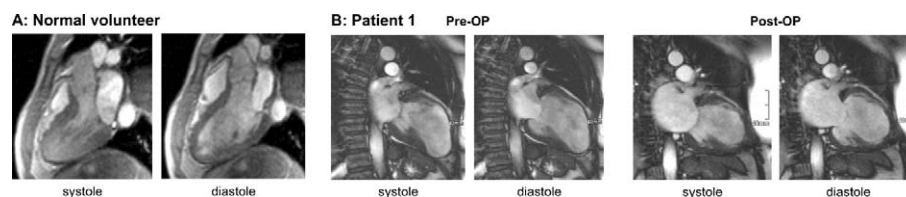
Long-axis cardiac magnetic resonance images of a heart from a healthy volunteer and a patient with dilated ventricle after myocardial infarction before and after surgical ventricular reconstruction. (Post-OP = postoperative; Pre-OP = preoperative.)
